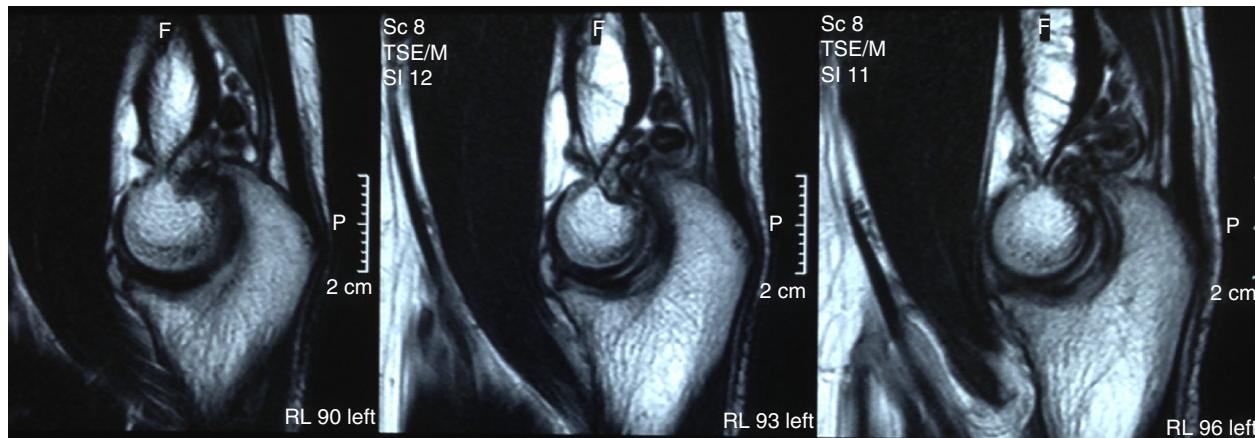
T1-weighted sagittal magnetic resonance imaging showing many free bodies in the fossa of the olecranon.
